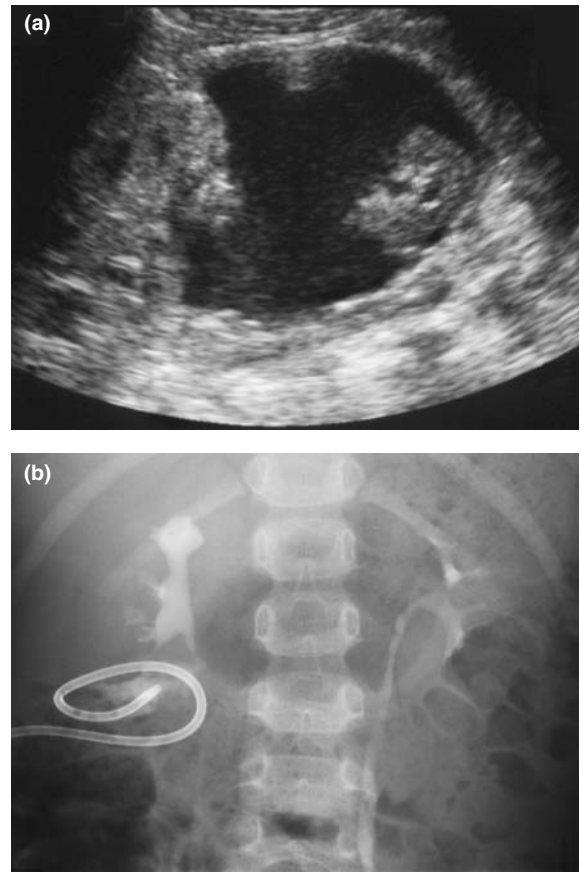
(a) Ultrasound scan demonstrating the avulsed lower pole of the right kidney lying free in a large perirenal urinary collection. (b) Pigtail catheter inserted percutaneously to drain an enlarging urinary collection despite 6 days of conservative management. IVU demonstrating leakage of contrast from the severed lower pole calyx. In this case surgical exploration was required some days later to close the leaking calyx and remove the necrotic, avulsed lower pole.
